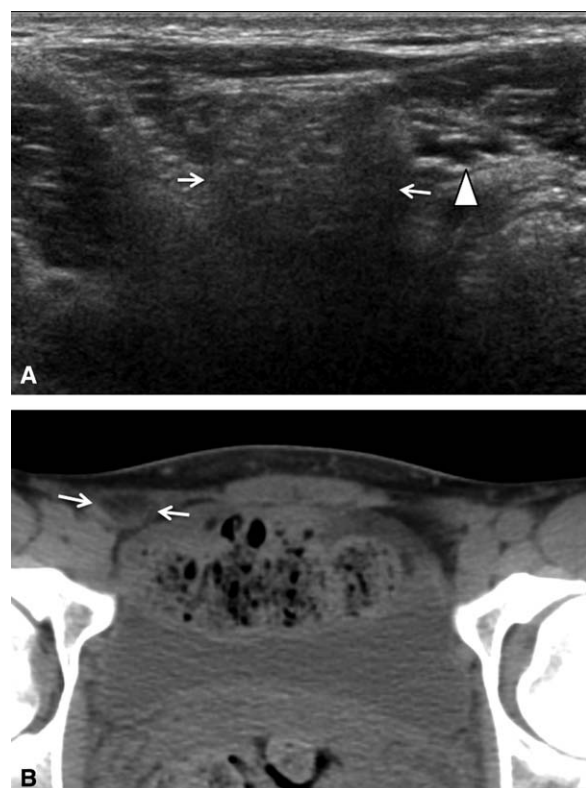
(A) Transverse sonogram of a right groin shows a suspected indirect inguinal hernia arising from the deep inguinal ring (arrows) lateral to the inferior epigastric artery (arrowhead). (B) Axial CT image from the same patient shows an inguinal canal lipoma (arrows). No hernia was present.
